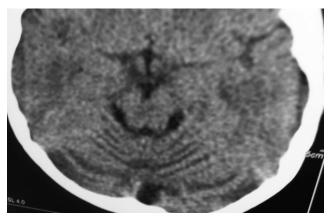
CT Scan of brain (axial view) showing widened folia of cerebellum
